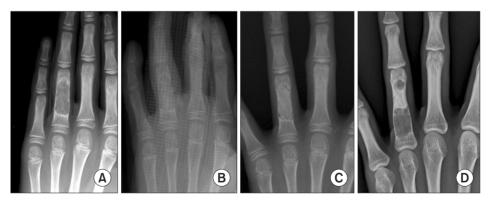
A 10-year-old boy with a enchondroma on the left fourth proximal phalanx shaft. (A) Preoperative plain radiograph showing nondisplaced pathologic fractures with cortical thinning due to the enchondroma. (B) Immediate postoperative plain radiograph showing autogenous bone graft without fixation. (C) Fracture union confirmed by plain radiography 1 year after surgery. (D) A recurrence of the tumor at the surgical site was discovered after an accident 9 years after surgery. He has no symptoms and is under close follow-up.
